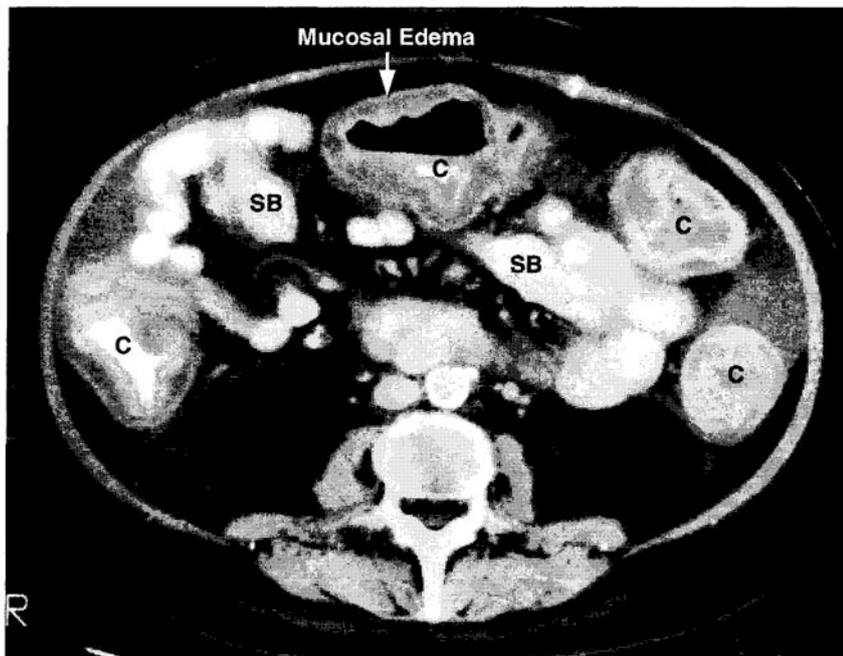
Contrast-enhanced CT scan of a patient with *C. difficile* enterocolitis. There is marked thickening of the wall of the colon (C), but not the small bowel (SB). (From Braley SE, Groner TR, Fernandez MU, Moulton JS. Overview of diagnostic imaging in sepsis. *New Horiz* 1993;1:214–230.) Image digitally enhanced.
